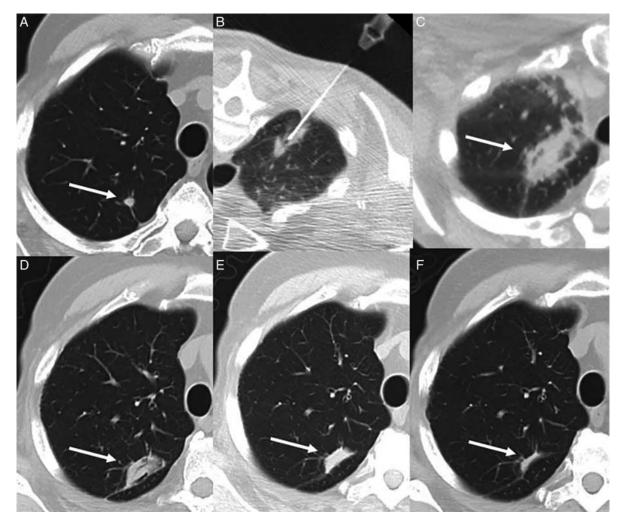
Evolution of percutaneous ablation changes on CT. A, Pretreatment CT demonstrating right upper lobe lung adenocarcinoma (arrow). CT during percutaneous radiofrequency ablation (B), and immediate postprocedure CT demonstrating GGO surrounding the tumor (arrow) (C). D, CT, 1 month after treatment, demonstrates dense opacity with early cavitation at the site of previous tumor and larger than the original tumor (arrow). E, CT, 3 months after treatment, demonstrates dense opacity with resolution of cavitation (arrow). F, CT, 12 months after treatment, demonstrates continued reduction in the size of the post-treatment opacity (arrow).
